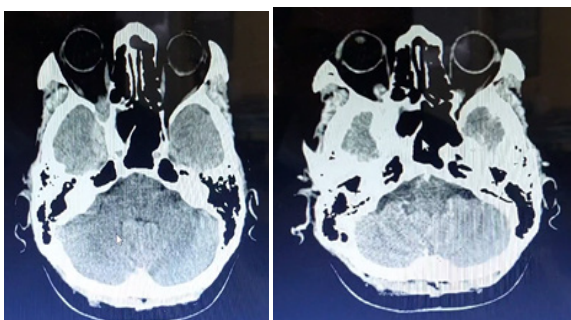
CT Examination Scan of the Head with contrast.
